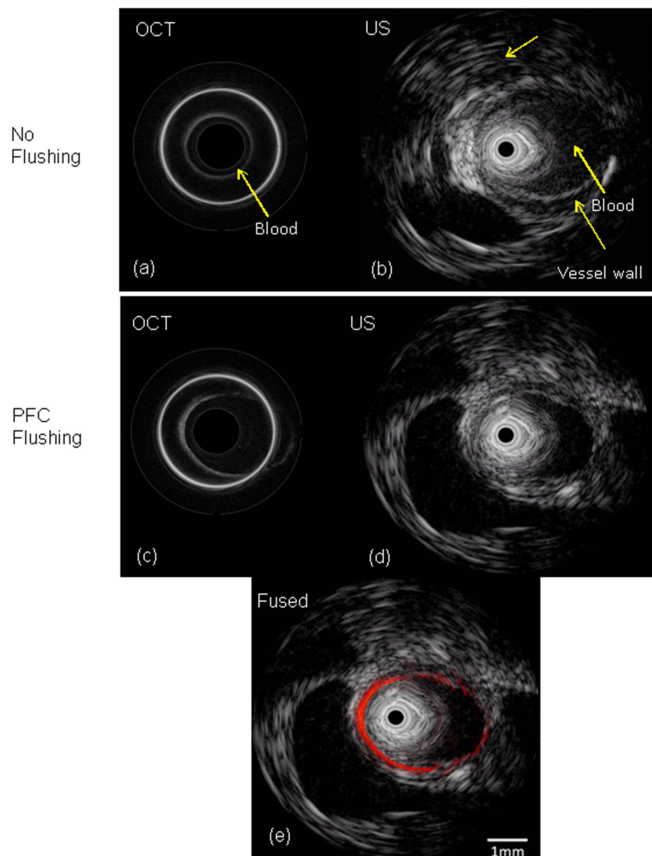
OCT (a) and ultrasound (b) images of rabbit abdominal aorta without flushing. OCT (c), ultrasound (d) and combined (e) OCT-US images with flushing
